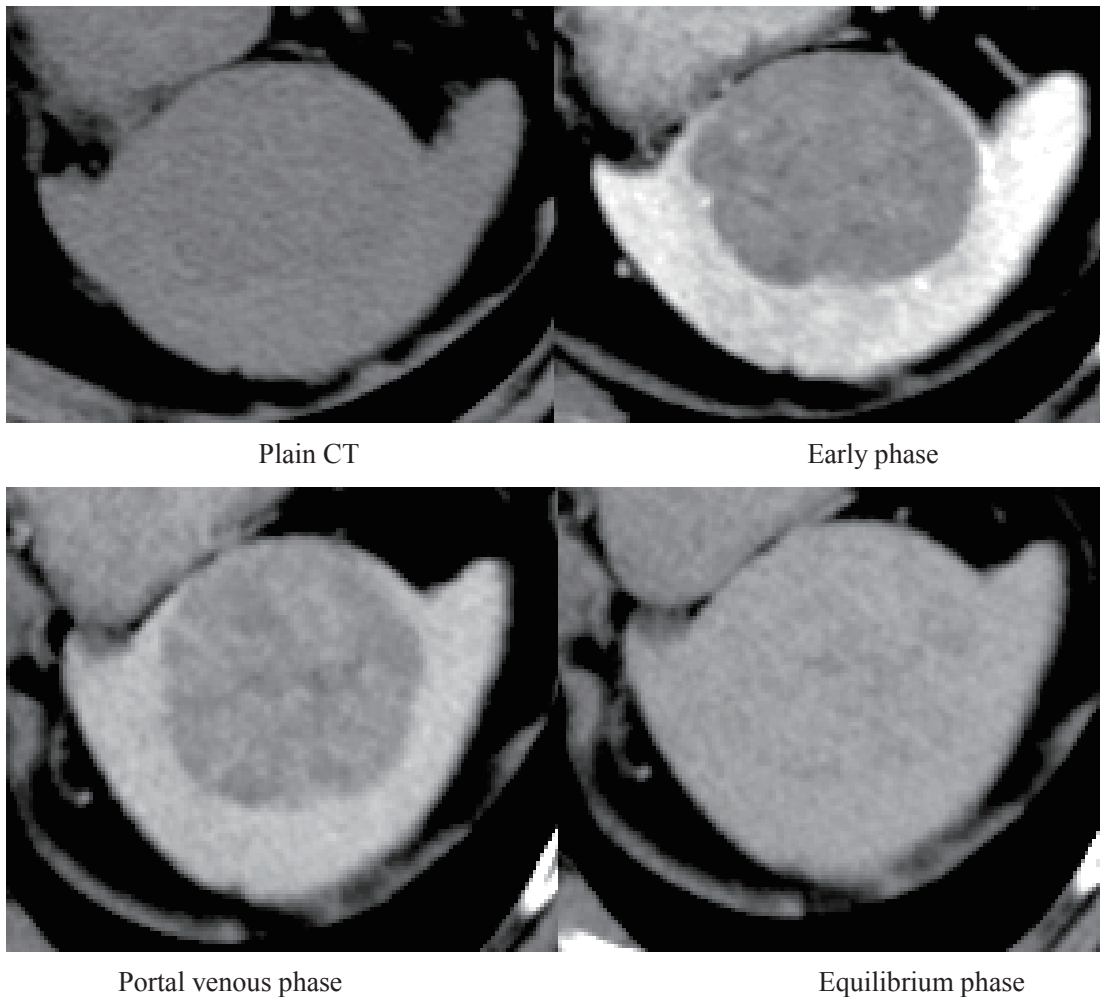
Abdominal contrast-enhanced computed tomography
